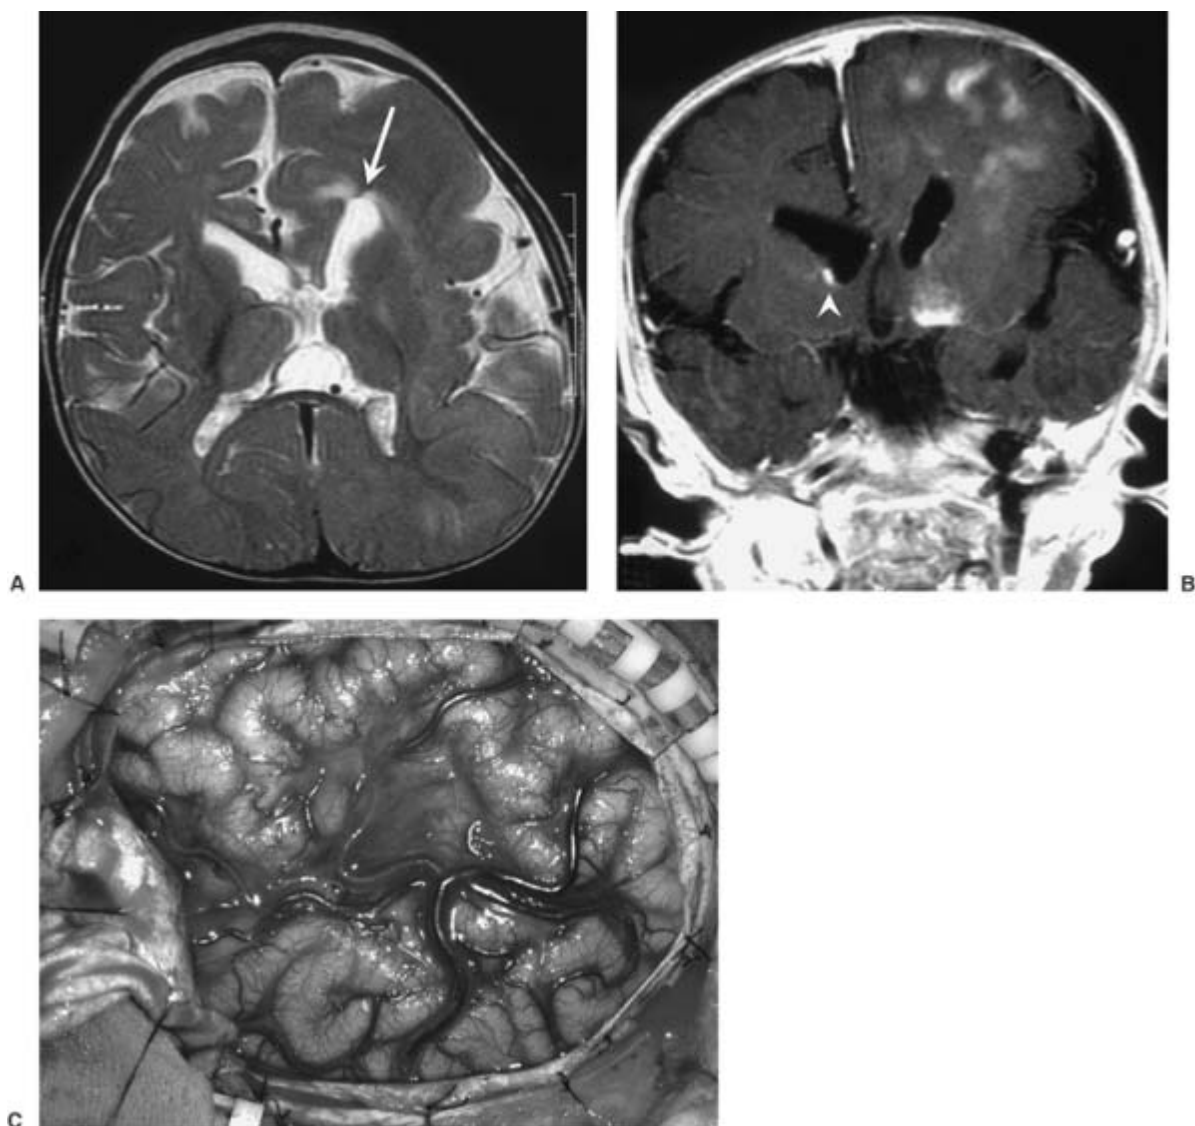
Hemimegalencephaly (HME) in a 13-month-old child with tuberous sclerosis complex (TSC). A: Axial T2-weighted image shows thickened gyri of the left frontal lobe, with an enlarged left cerebral hemisphere, suggesting HME. Most of the white matter in the left cerebral hemisphere is poorly myelinated. A well-defined subcortical hyperintense T2-weighted signal is noted in the left anterior cingulate gyrus, consistent with a tuber (*white arrow*). B: Postcontrast T1-weighted coronal image shows patchy foci of enhancement in the left cerebral hemispheric white matter, suggesting locations of tubers. A small, round focus of enhancement in the inferior aspect of the right frontal horn of the lateral ventricle (*white arrowhead*) represents a subependymal nodule, also characteristic of TSC. C: Intraoperative view of the left cerebral hemisphere showing multiple areas of abnormal cortical organization. The frontal lobe is in the upper left and the parietal lobe is in the upper right of the image.
